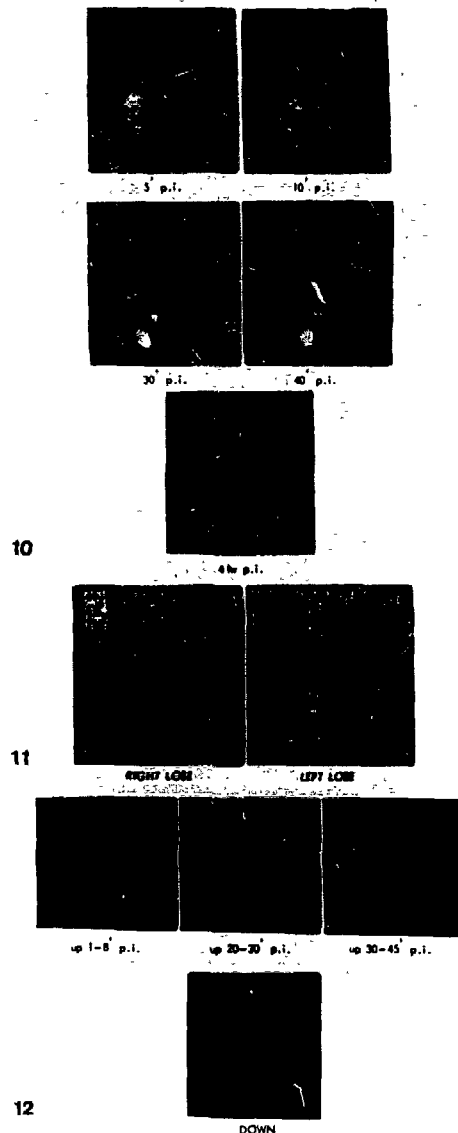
10-12 Cholescintigraphy in a patient with diffuse liver metastases.
